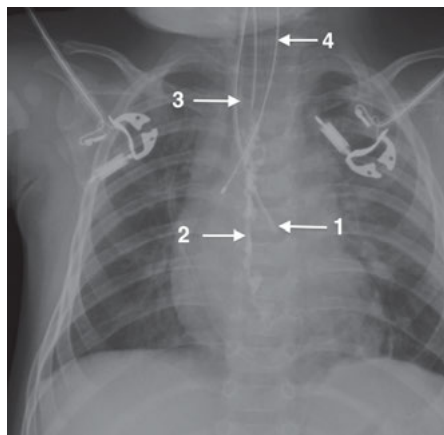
Chest x-ray of an infant showing endobronchial blocker in the left main stem bronchus (1), epidural catheter and epidural contrast (2), endotracheal tube in the trachea (3), and temperature probe in the esophagus (4).
